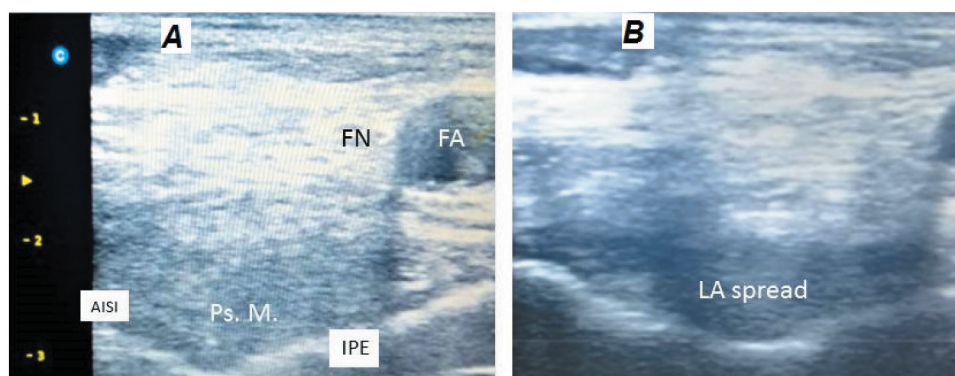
Ultrasound view showing land marks for the PENG block (A) and local anesthetic spread (B). FA: femoral artery, FN: femoral nerve, IPE: iliopsoas muscle and tendon, Ps.M: Psoas muscle and tendon, LA: local anesthetic.
